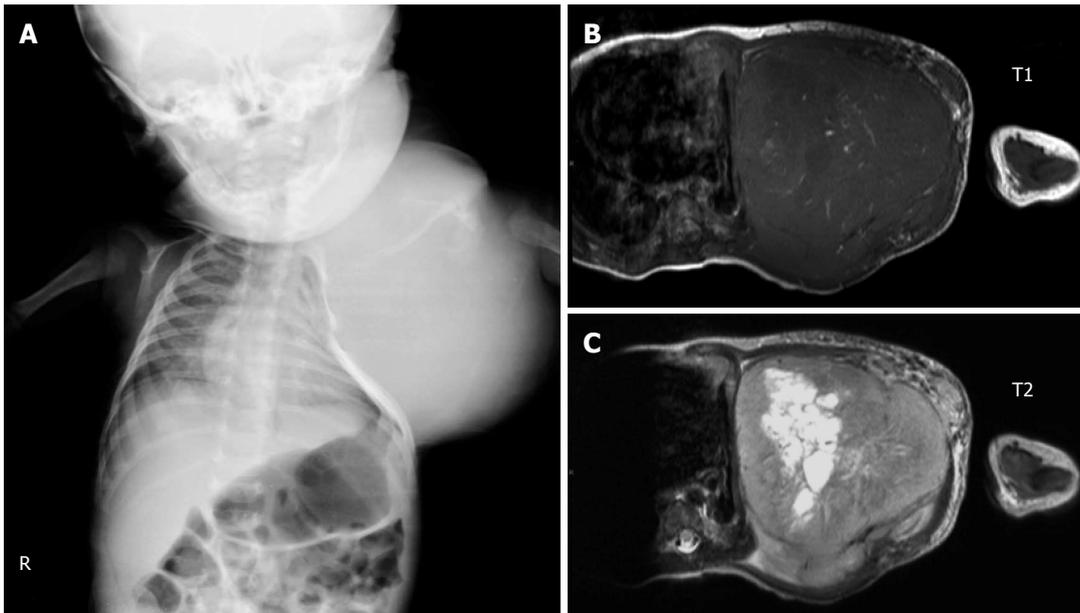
Plain radiographic and magnetic resonance images demonstrating deformity of the left chest wall caused by a congenital infantile sarcoma (A, B and C).
